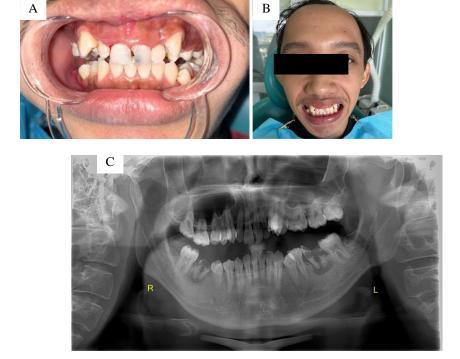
(A) Clinical photo (B) Photo of the patient smiling (C) Panoramic radiography examination.
